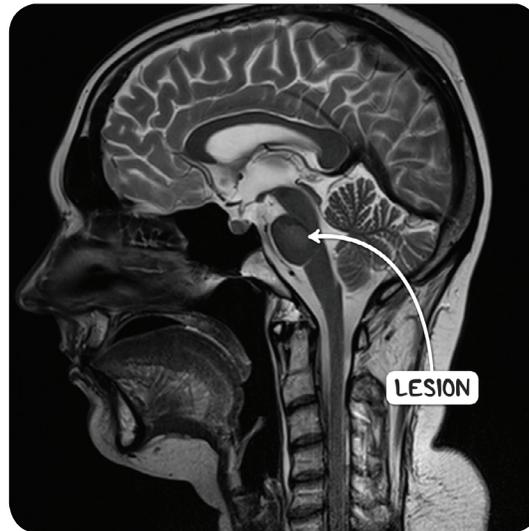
An MRI scan of the head and neck in the sagittal plane demonstrating a hypointense lesion in the pons of an individual with central pontine myelinolysis.
